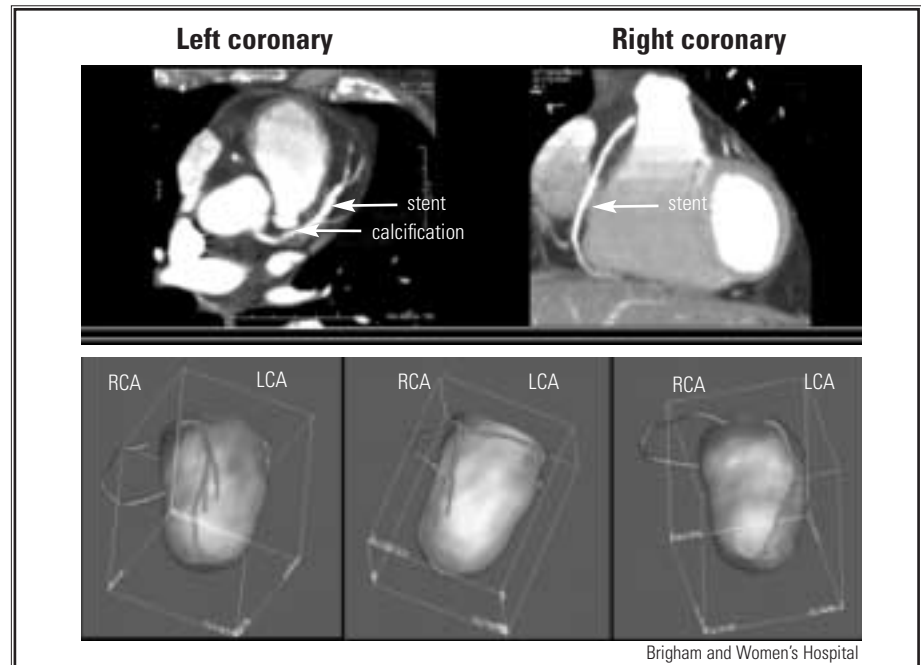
Top: Cross-sectional CT images of left and right coronary arteries following administration of IV contrast, obtained with eight-slice PET/MDCT scanner (GE Medical Systems). Images demonstrate “blooming” artifact caused by metallic stents and coronary calcium, which makes it difficult to determine the presence of flow-limiting stenoses. Bottom: Fusion of functional myocardial perfusion PET data (3D polar map) and CT coronary angiographic information. Functional PET information demonstrates no evidence of stress-induced ischemia.
